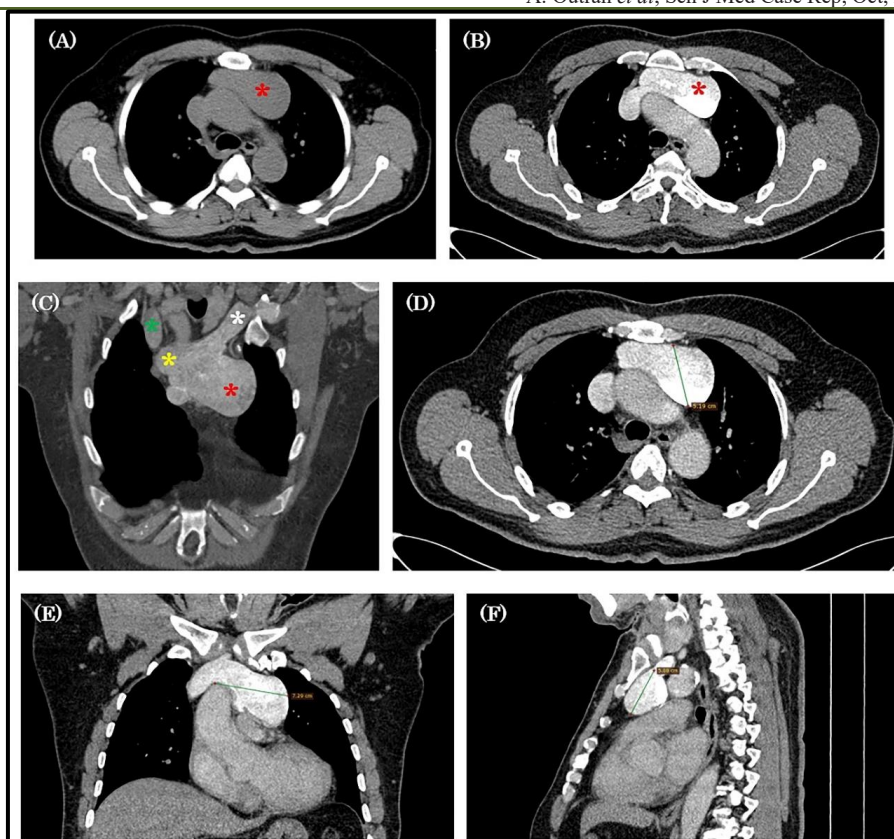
Contrast-enhanced thoracic CT images demonstrating a saccular aneurysm of the left brachiocephalic vein (red asterisk). (A–B) Axial views showing a well-defined, contrast-filled vascular structure located in the anterior mediastinum with pooling of contrast in the most dependent portion of the sac, consistent with gravity-dependent contrast stagnation. (C) Coronal reconstruction showing continuity between the aneurysm (red asterisk), left subclavian vein (white asterisk), the origin of superior vena cava (yellow asterisk), and right brachiocephalic vein confluence (green asterisk). (D–F) Axial, coronal, and sagittal reconstructions with size measurements of the aneurysmal sac
